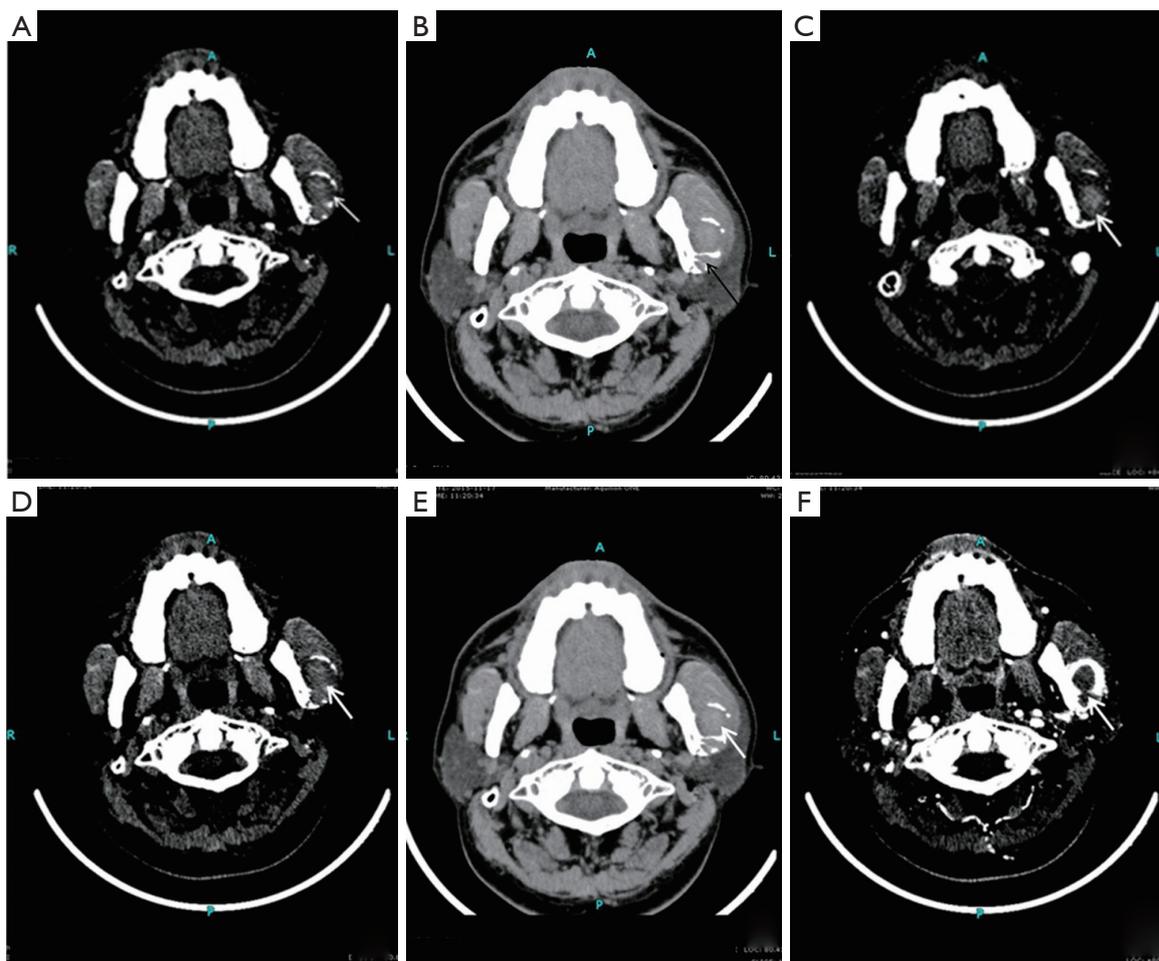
Computed tomography of the lesion in the left ramus of the mandible: the mass was located in the ascending ramus of the mandible and its boundary was unclear. It invaded the condyle. Bone was absorbed by compression and displaced to the depth of masseter muscle. Bone in sigmoid notch also expanded upward.
